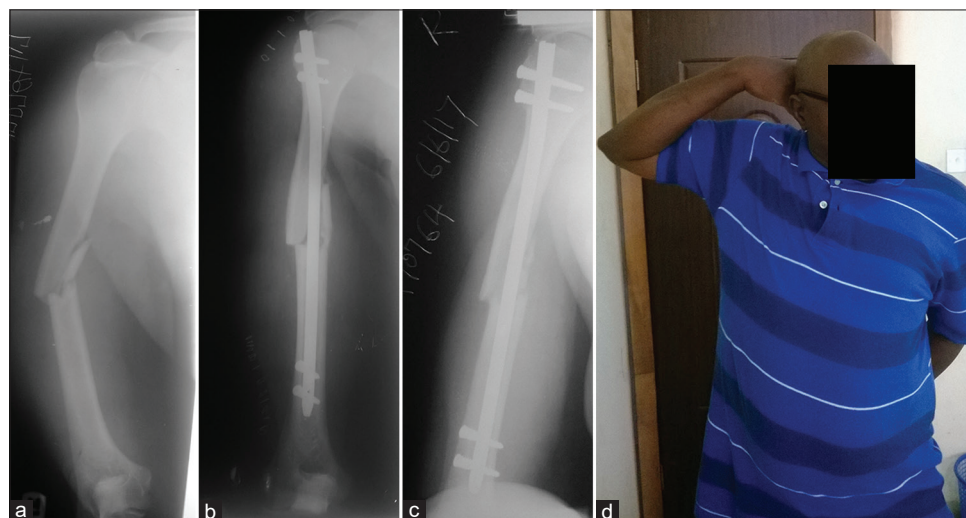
(a) Pre-operative radiograph showing Arbeitsgemeinschaft für Osteosynthesefragen 12-B1 fracture. (b) Immediate post-operative radiograph showing standard surgical implant generation network intramedullary nail. (c) Three-months post-operative radiograph. (d) Photograph showing the index patient performing shoulder Flexion, abduction, external rotation exercise at 3 months
